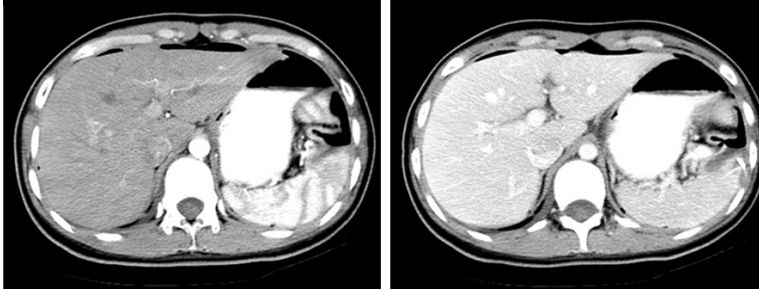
A postoperative CT scan, done at the 1-week follow-up, showing that the residual spleen after SPLPS had good blood supply.
